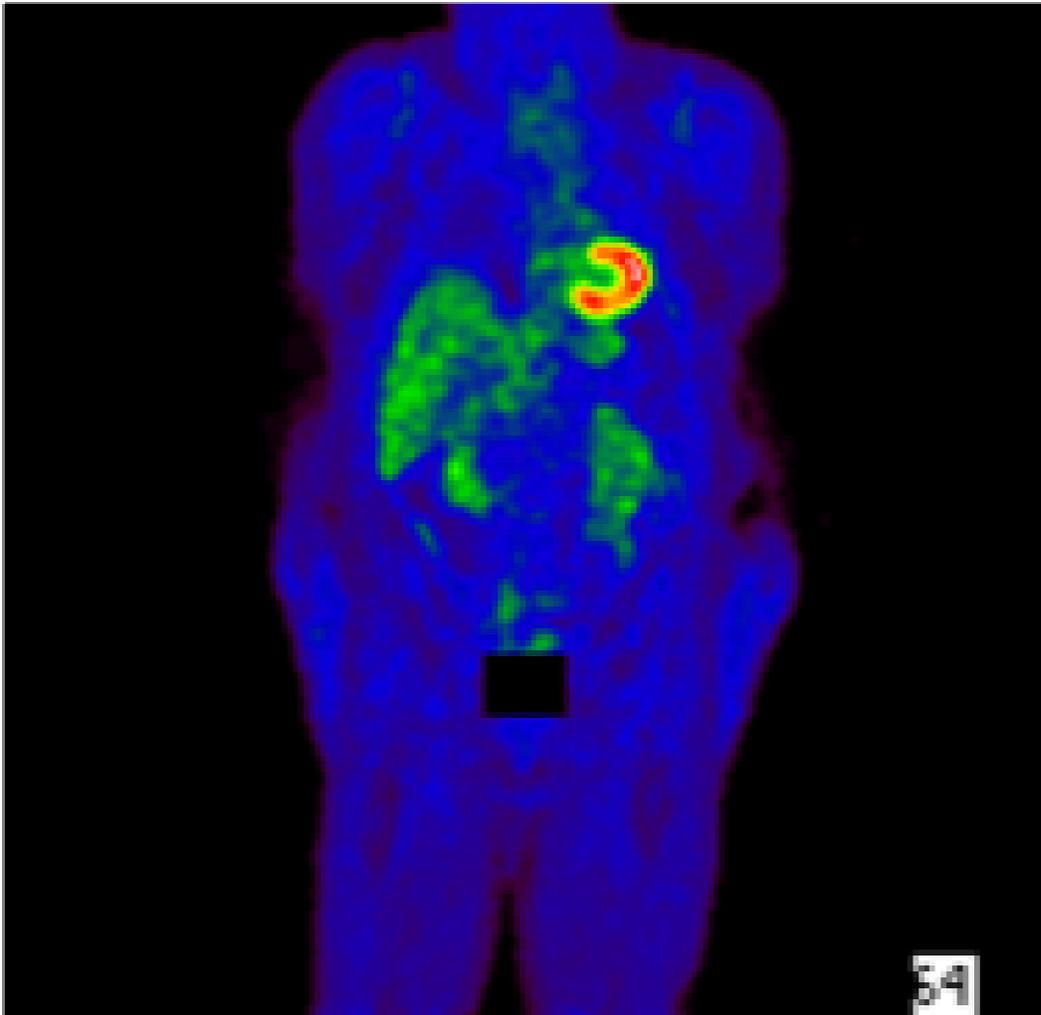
FDG PET for a 69 year old female with chronic thyroiditis and Type 2 DM. Patient has a history of depression and a HbA1c 8.1% with squamous lung cancer in remission post video thorascopic resection. The PET data yields Sn 1.94 and her fibrosis index is 0.82, consistent with probable hepatic steatosis or early fibrosis (values > 0.65 fibrosis index are consistent with fibrosis), despite normal AST 14 and ALT 16 (normal < 40). Also, despite minor hyperglycemia, blood sugar 157 mg/dl fasting, myocardial activity is prominent, consistent with minor cardiomyopathy, confirmed on an earlier PET as well and by mildly reduced LVEF 48%. Patients with abnormal adrenal function have a tendency to develop hepatic inflammation and elevated Sn: this patient's baseline AM cortisol was 5.4, borderline low. Remarkably, the methodology used for PET apply also to FDG PET studies: this patient's value would be only slightly above the regression line in Fig. 5 for Ln Sn (on y axis) and the fibrosis index (on x axis).
